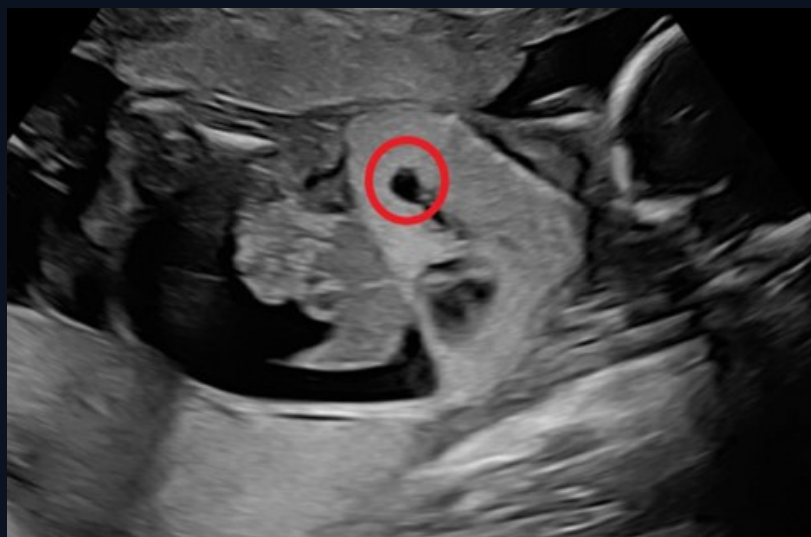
This coronal oblique greyscale ultrasound image demonstrates a fluid filled structure (red circle) opposite of the heart, in the right lung. Presumably, this structure is causing the high airway obstruction, leading to CHAOS syndrome.
